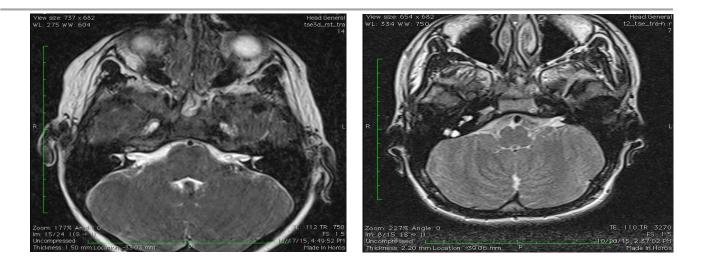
MRI axial section 3D FIESTA showing left-sided cochlear aplasia
